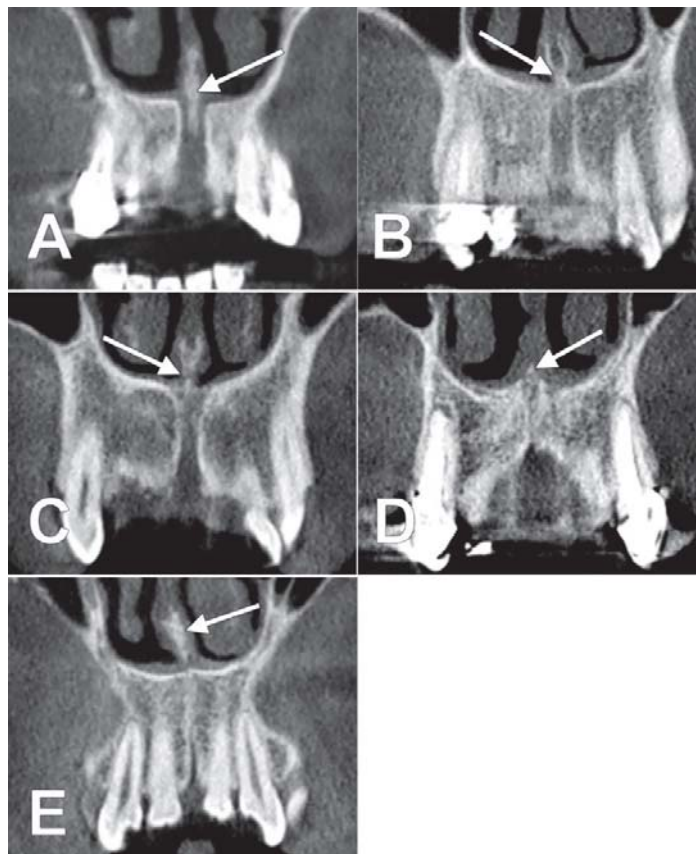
Morphological possibilities of the nasomaxillary/septo-premaxillary crest. Orthogonal coronal Cone Beam CT slices. A. Type I. B. Type II. C. Type III. D. Type IV. E. Type V
